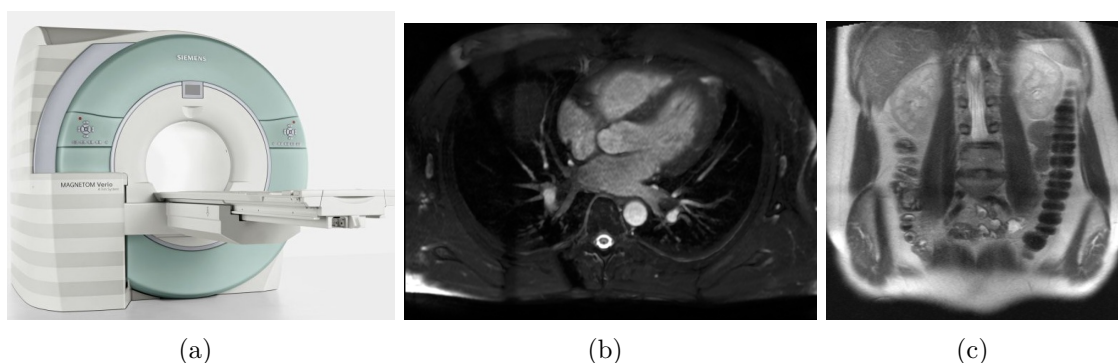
(a) Stationary MRI scanner system (Siemens Verio, image courtesy of Siemens Healthcare) (b) 2D cardiac MRI scan (c) 2D abdominal MRI scan.
